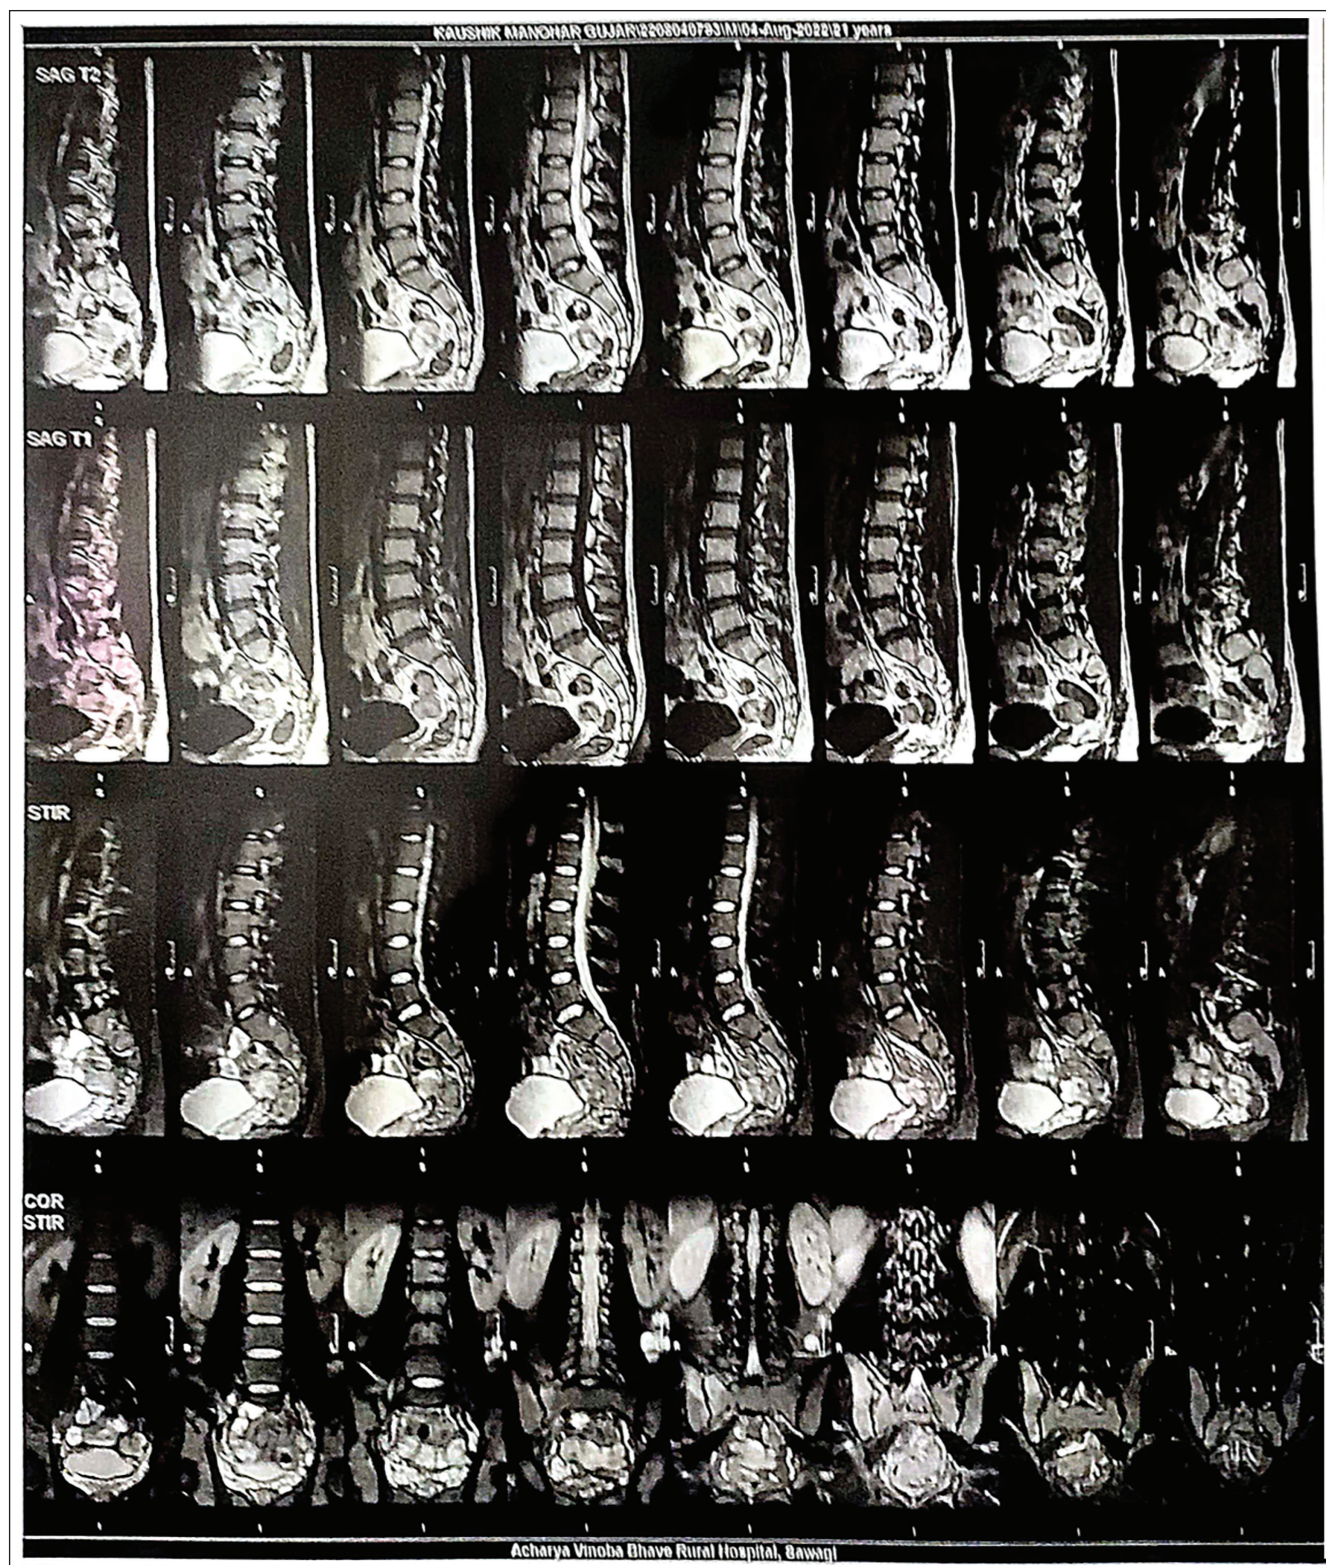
MRI Lumbar Spine Shows—The Bulge at L4-L5 and L5-S1 Disk Level seen in MRI Lumbar Spine.
